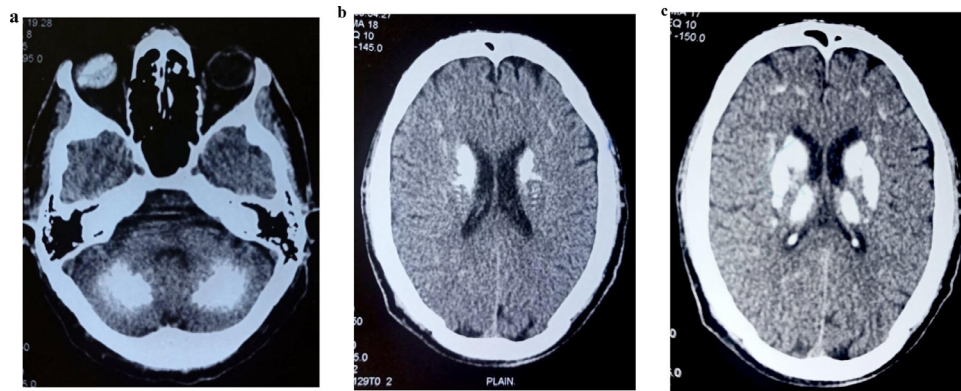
(A) Axial noncontrast computerized tomographic (CT) image depicts calcification in the right globe (right globe with a white haze). (B) Nonenhanced computerized tomographic (CT) scan of the brain demonstrating bilateral symmetrical calcifications in the basal ganglia. (C) Axial noncontrast computerized tomographic (CT) scan of the brain shows extensive bilateral symmetrical calcification in the head of caudate nuclei, putamen, globus pallidus, thalami, cerebellar dentate nuclei, centrum semiovale, and subcortical white matter.
